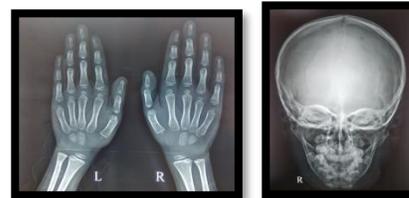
The orthopantomogram revealed localized spacing of teeth in the lower arches, decayed teeth as well. Hand and wrist radiograph revealed delayed growth. AP skull view shows presence of succedaneous tooth buds.
